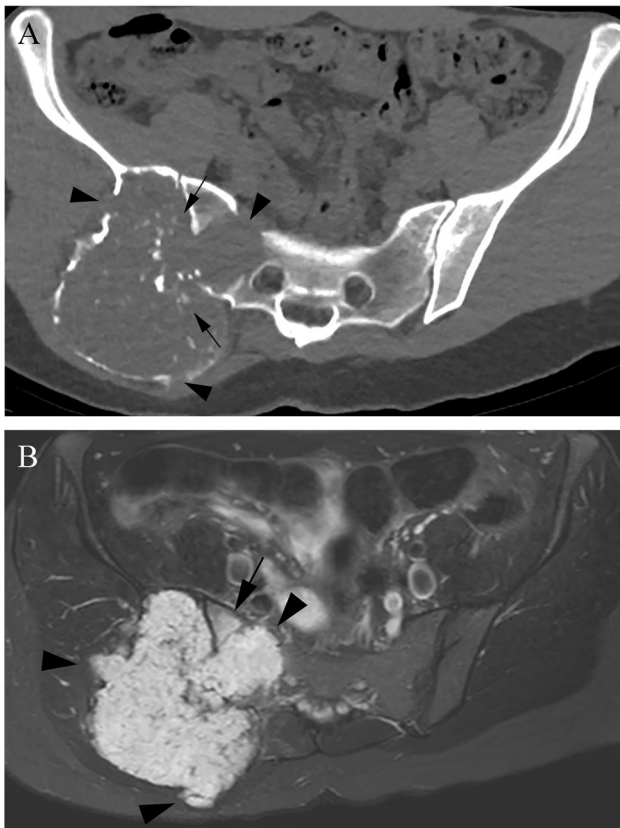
A 27-year-old woman with grade 2 and 3 chondrosarcoma in the right ilium. (A) Axial CT image shows a lytic lesion causing endosteal scalloping, expansile remodeling, and cortical destruction with soft tissue extension (arrowheads) in the right sacral neuroforamen and gluteal muscles. The lesion contains multiple linear and curvilinear calcifications (arrows). (B) Axial T2-weighted fat-suppressed image shows multiple high-T2 signal lobules without internal fat, extraosseous mass (arrowheads) with sacral marrow edema (arrow)
